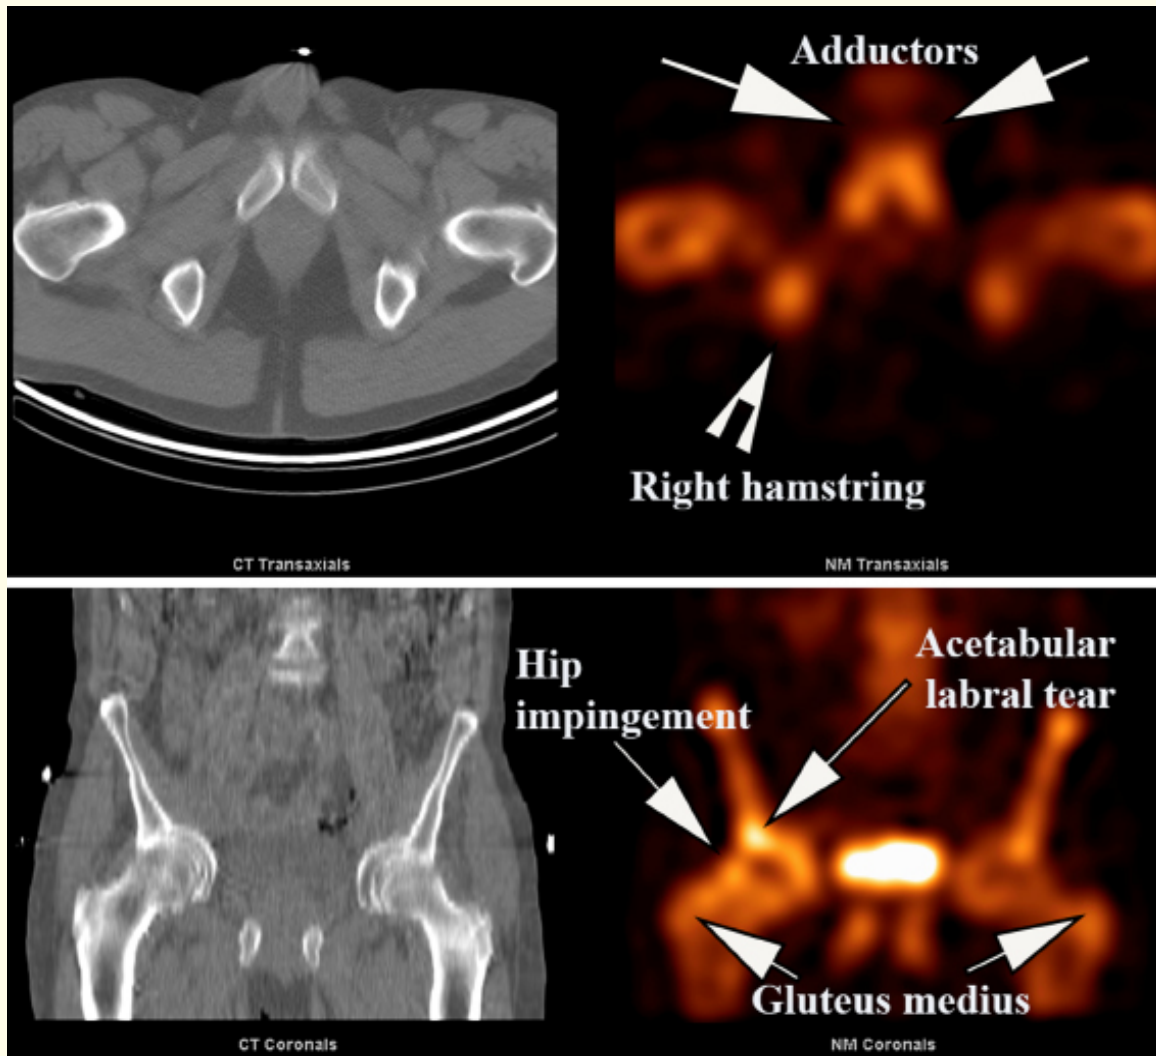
Scintigraphic SPECT/CT study in the same patient from figure 3A. The top panel shows the enthesopathic changes at the sites of adductor (arrows) and right hamstring tendon (arrowhead) insertion. The lower panel shows gluteus medius tendon enthesopathy on both sides and the secondary right hip impingement of the lateral femoral head against the acetabulum that was torn. This was in fact the presenting symptom that led to the diagnosis of the sacroiliac joint incompetence.
